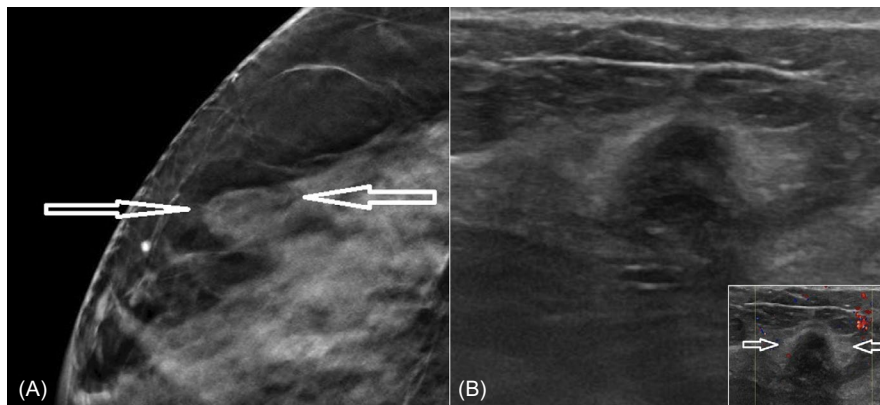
Imaging features of breast chondrolipoma. (A) Cranio-caudal tomosynthesis of the outer quadrants of the right breast showed an oval-shaped nodularity (arrows) with sharp margins that was devoid of calcifications (B). Ultrasounds revealed the inhomogeneous echostructure of the nodule which was avascular at echo-doppler analysis (inset) and was surrounded by a hyperechoic peripheral halo [Color figure can be viewed at wileyonlinelibrary.com]
